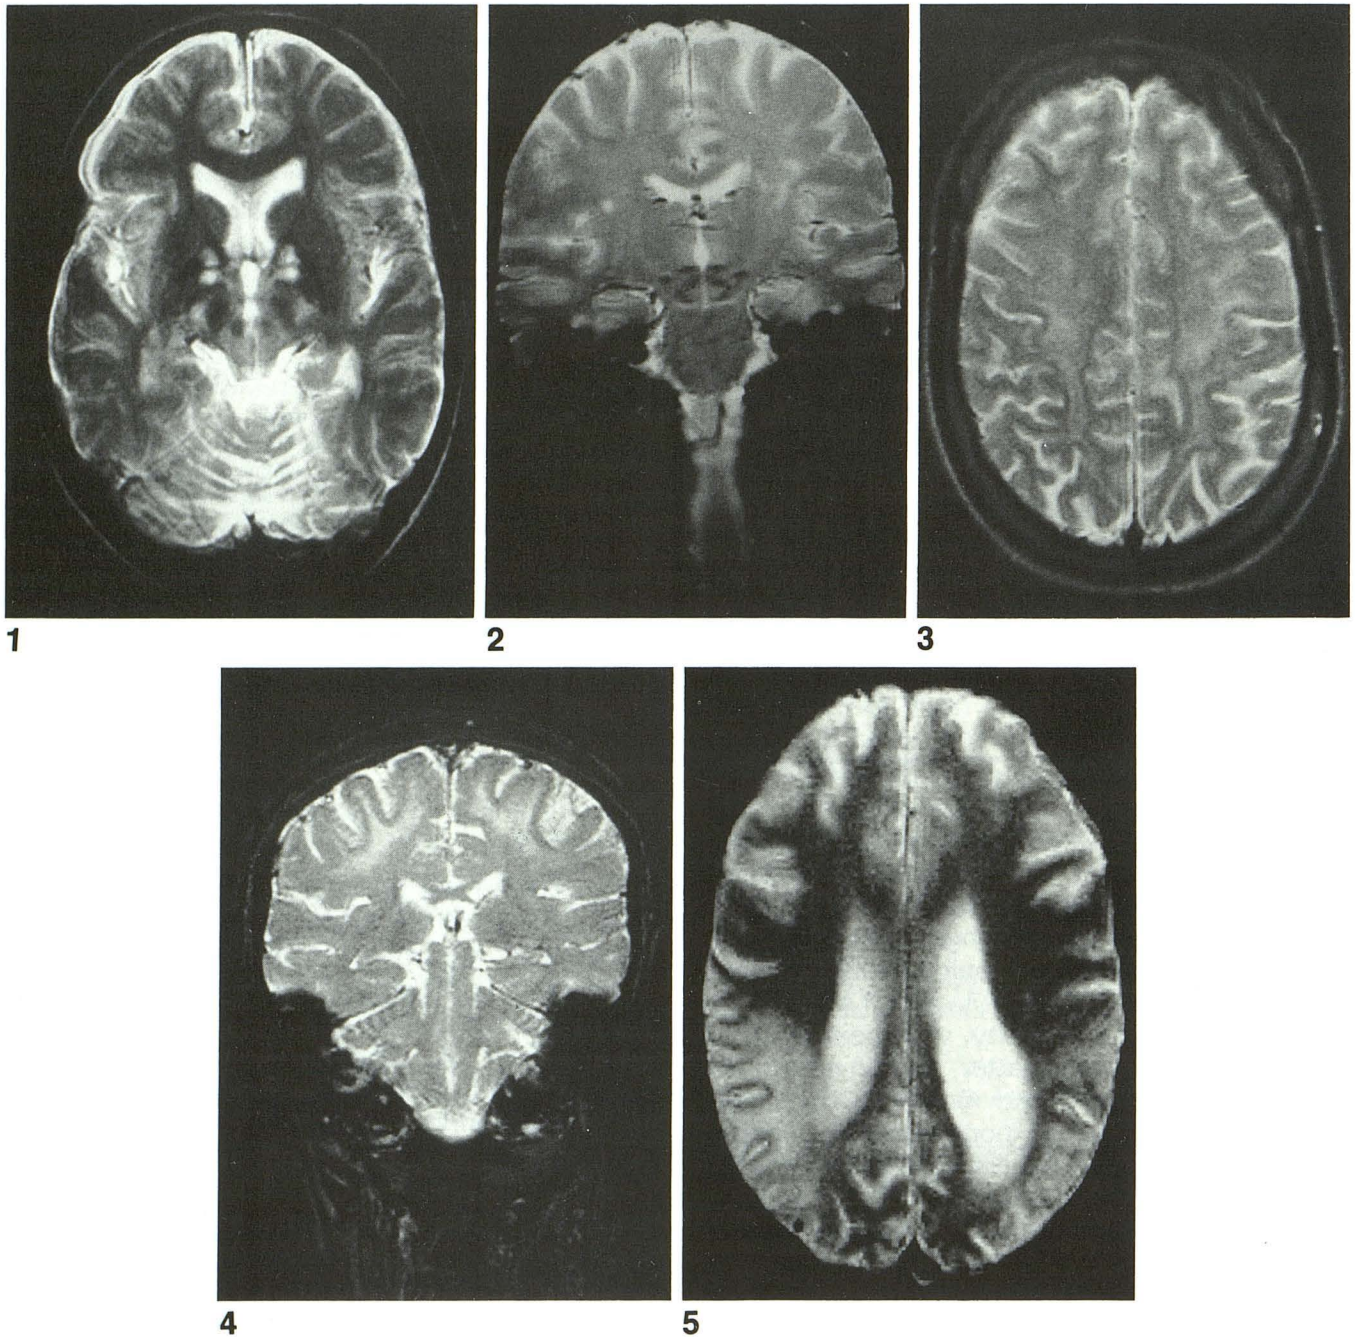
This 37-year-old woman (case 9) had severe cerebellar symptoms. The axial T2-weighted gradient-echo image (fast field echo 800/34/2, 15° flip angle) shows symmetrical lesions in the posterior branch of the internal capsule and widening of the subarachnoid space.
